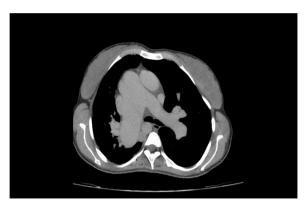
An axial view of a computed tomography scan showing the pulmonary arteries and right pulmonary artery aneurysm
